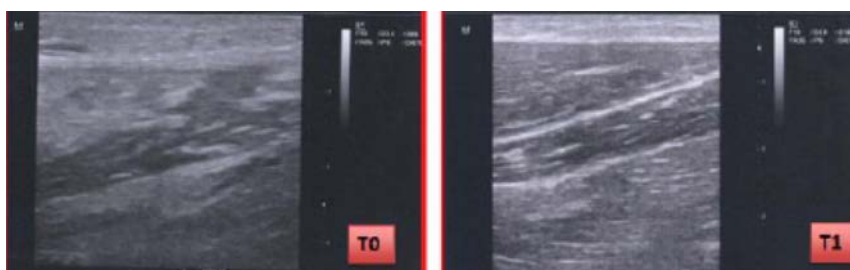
Ultrasound examination pre- (T0) and after treatment (T1).
